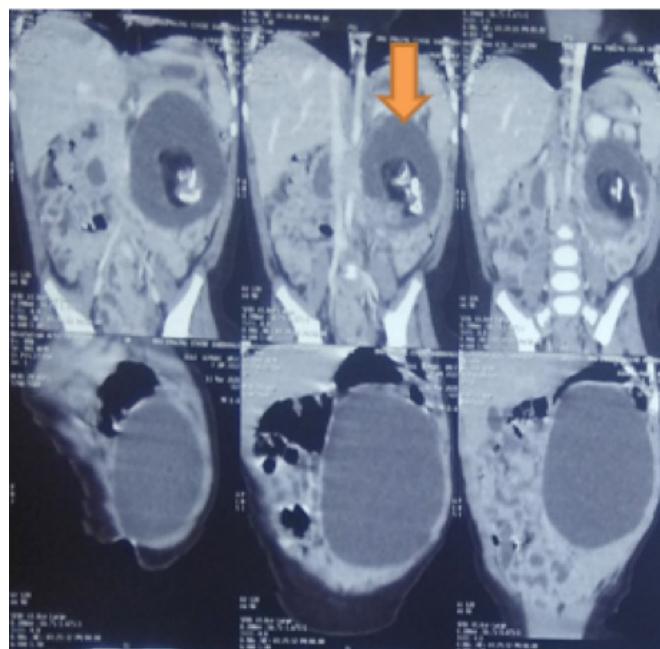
Computed tomography scan pictures showing the presence of organized bone in the cystic mass.
